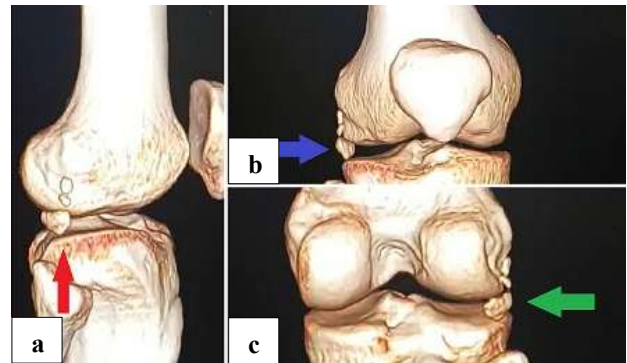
CT scan of the right knee, highlighting (a) a loose body in the lateral view (red arrow), (b) anterior view (blue arrow), and (c) posterior view (green arrow).
